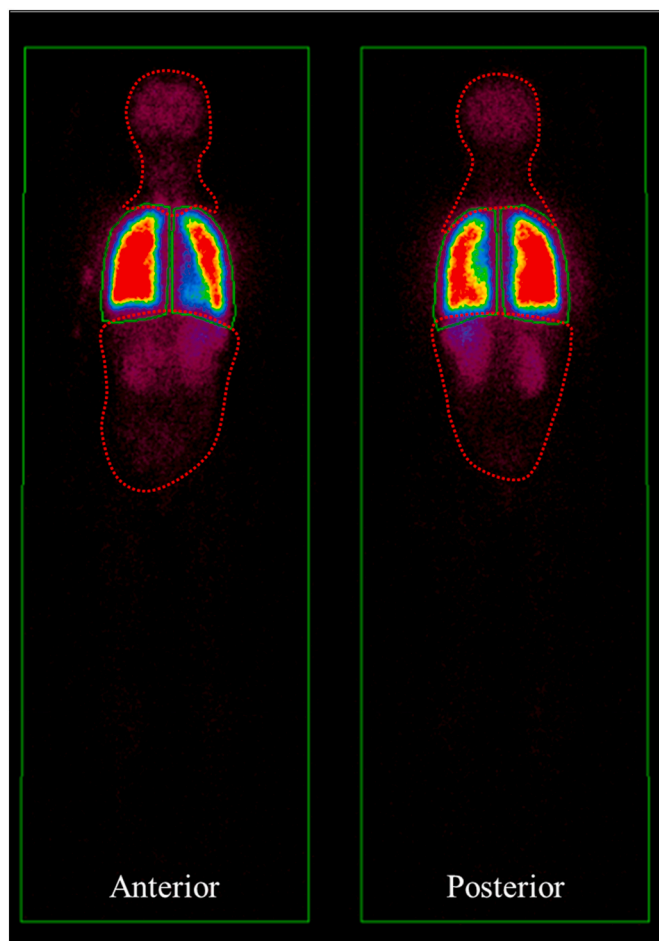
Pulmonary perfusion scintigraphy shows accumulation in the brain and kidneys, in addition to the lungs, suggesting the presence of right-to-left shunts (dotted area). The shunt fraction was 16.4%.
